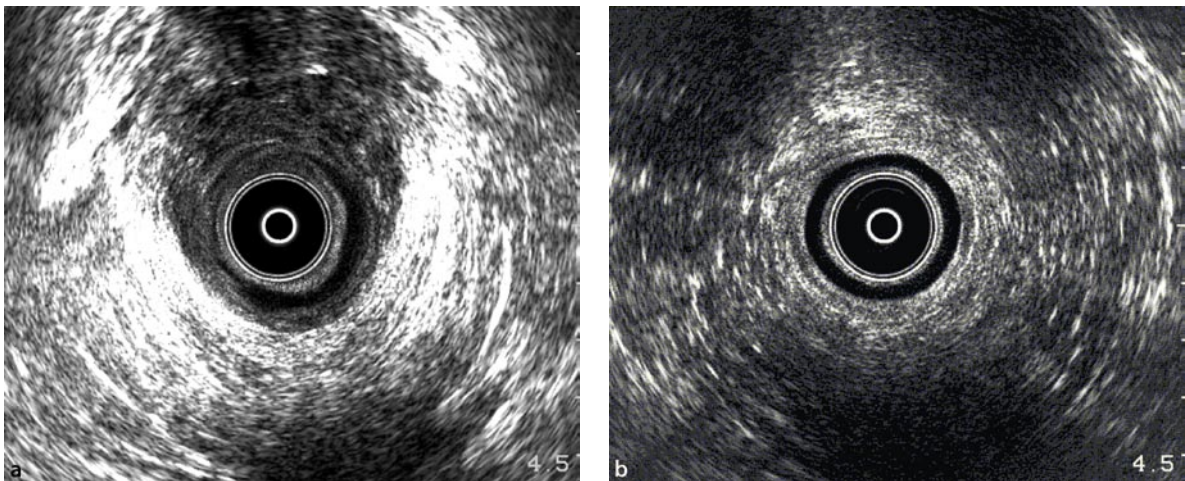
a Endoanal ultrasound: female, 34 years, birth trauma, defect of the internal anal sphincter from 9 to 2 o'clock and defect of the external anal sphincter from 10 to 2 o'clock. b Physiologically "normal" sphincter on endoanal ultrasound
